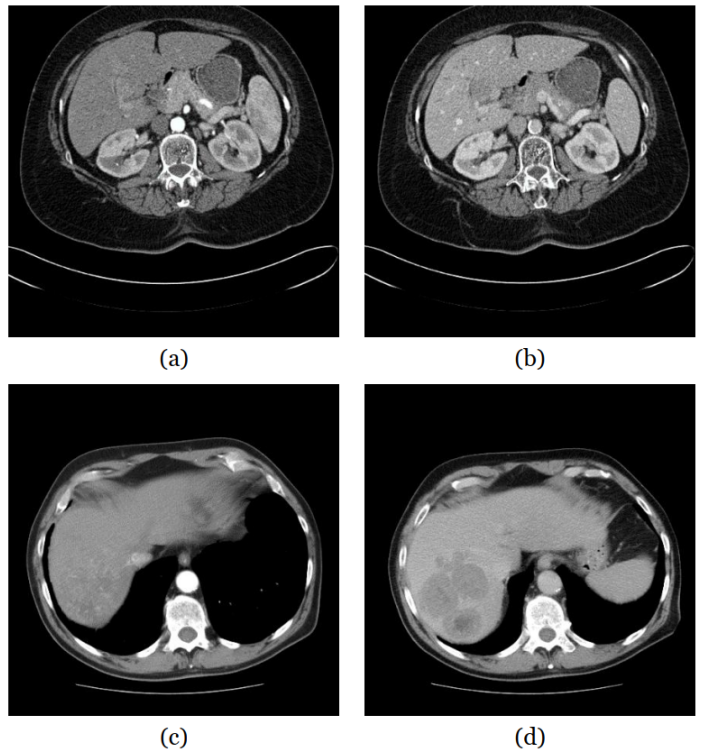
Appearance of early and late-stage HCC in contrast CT scans. (a) *Arterial scan*: The region slightly left of the centre top of the image shows a region slightly brighter than its surroundings. (b) *Portal venous scan*: The same region in the arterial scan is shown to be slightly washed out, indicating a likely tumour. (c) *Arterial scan*: There are no clear signs indicating the presence of a cancerous tumour. The bright spot has no matching washout. (d) *Portal venous scan*: The particularly dark regions in the bottom left of the image indicate multiple cancerous tumours.
